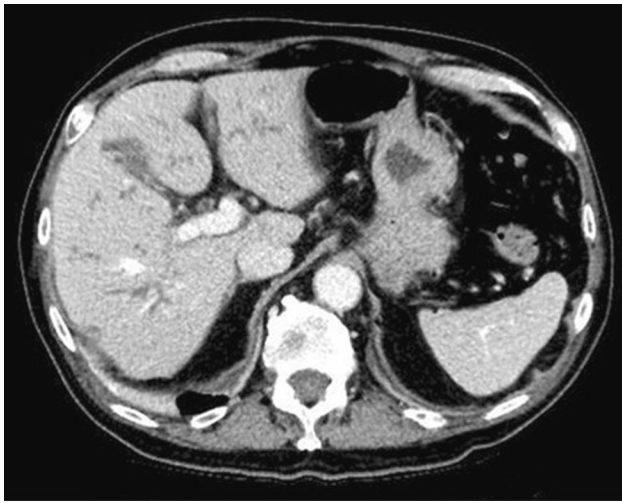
CT demonstrating new diffuse intrahepatic biliary dilatation with periductal enhancement suggestive of a diffuse cholangitis picture
